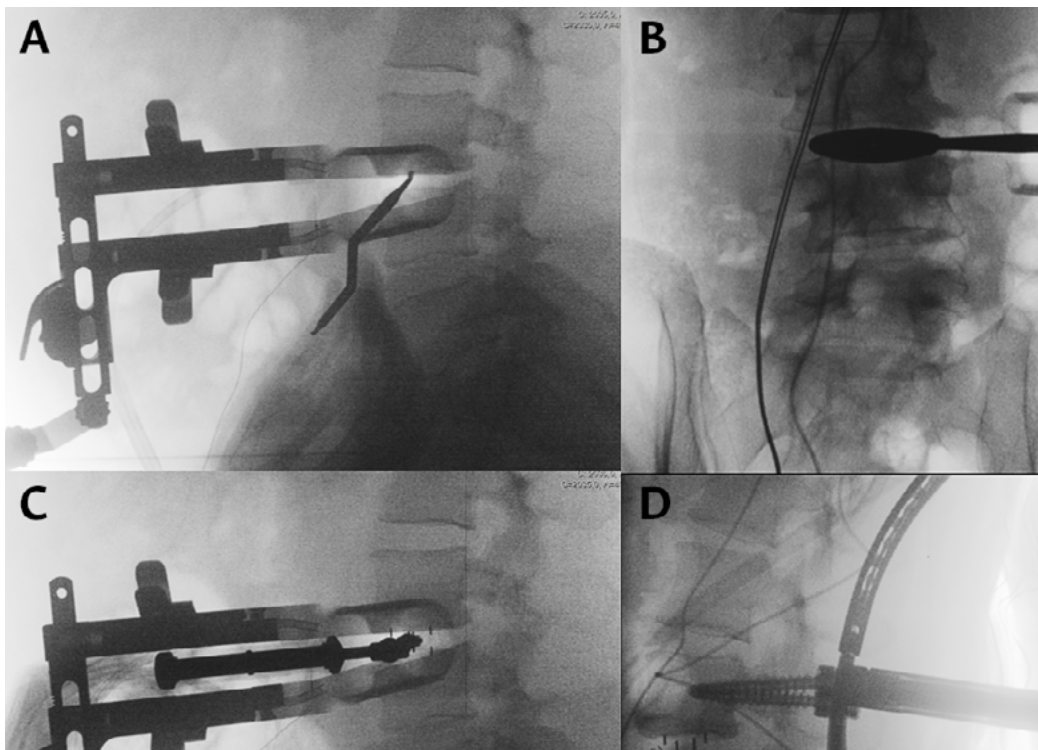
Intraoperative X-ray images. 3A. Dissector marking of the middle of the vertebral disc. 3B. Calculation of the definitive implant size by testing after discectomy. 3C. Placement of the interbody cage. 3D. Pedicle screw placement with the usual percutaneous technique.
